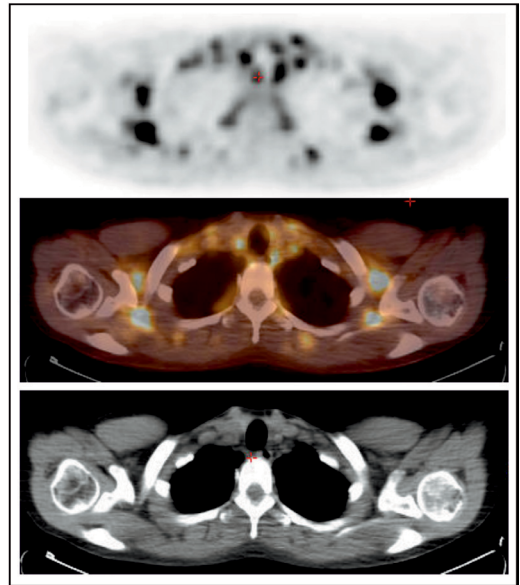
By fusion of a PET image (top) and a CT image (bottom), an anatomical location of the radiotracer uptake can be visualised in a CT-PET image (middle).
